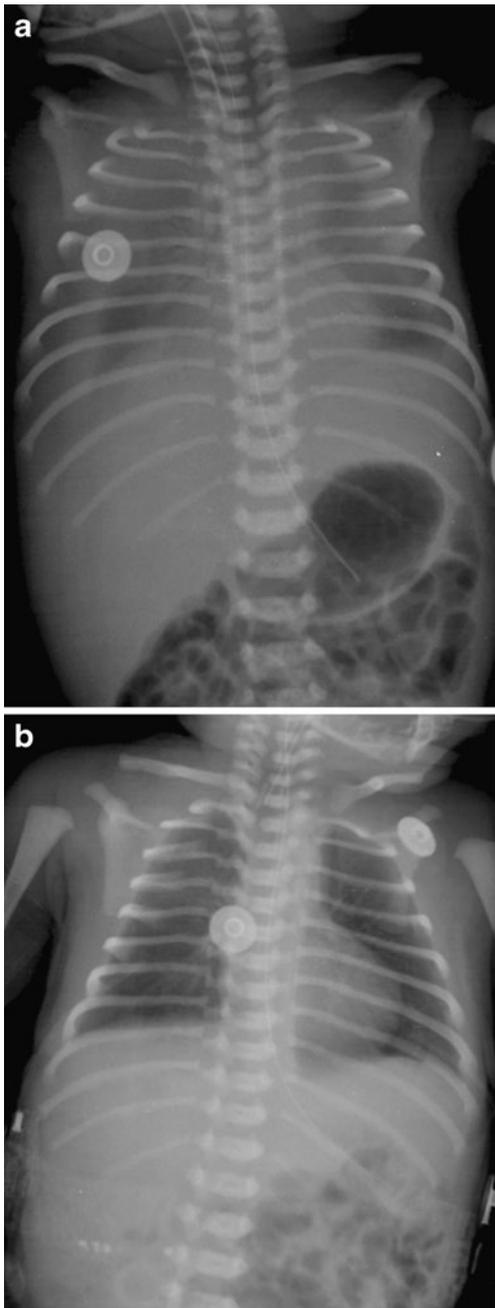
a. Emergency chest radiograph showing bilateral pleural effusions with passive collapse of underlying lung. b. Follow up chest radiograph showing complete resolution of pleural effusions and lung expansion
